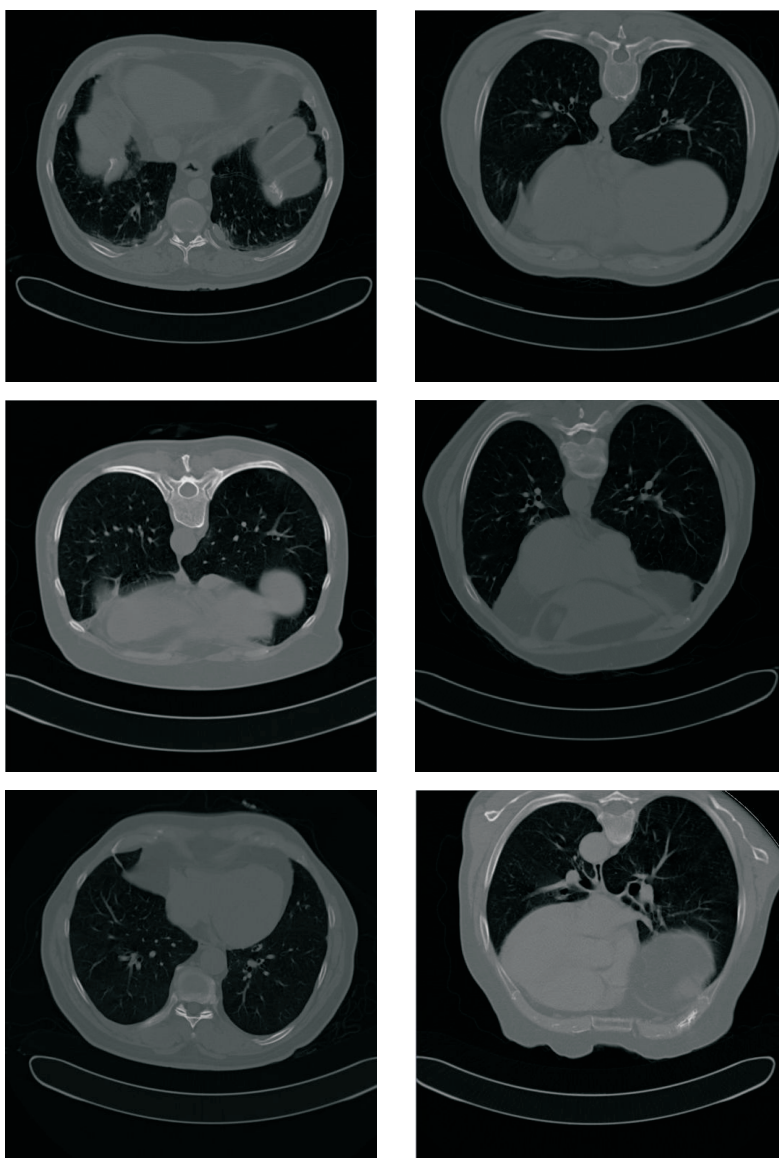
The top slices of six abdominal CT data sets.
